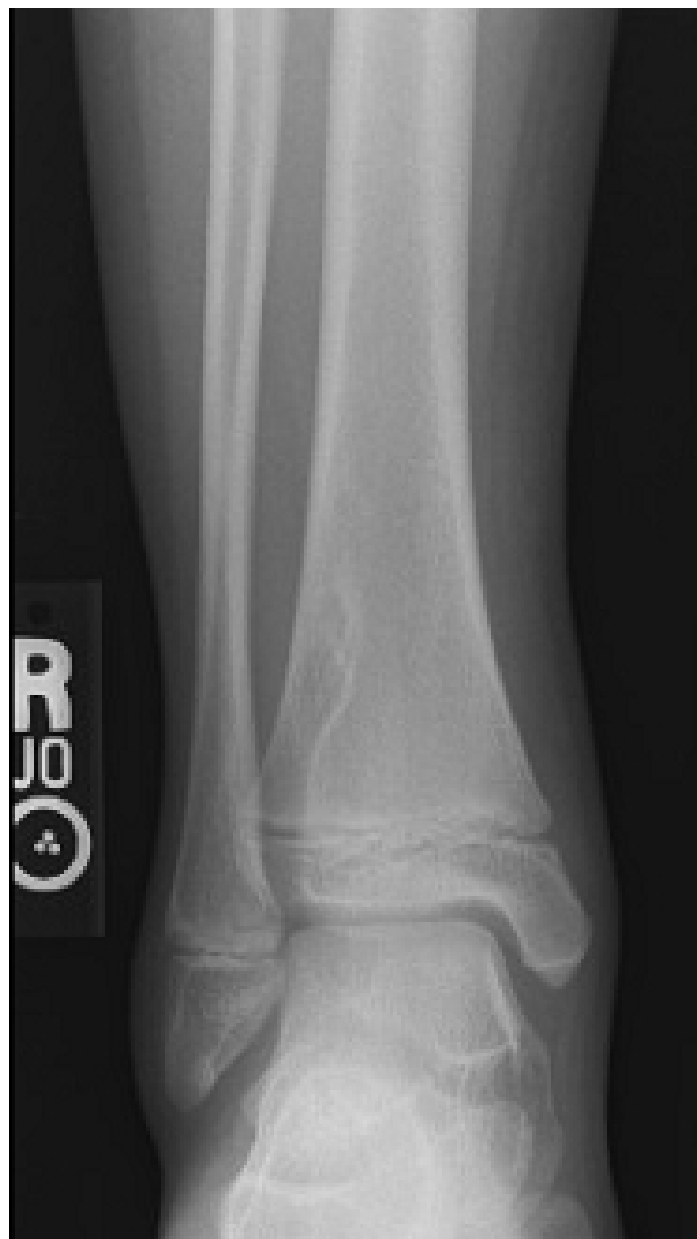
Initial AP radiograph of normal right ankle.
